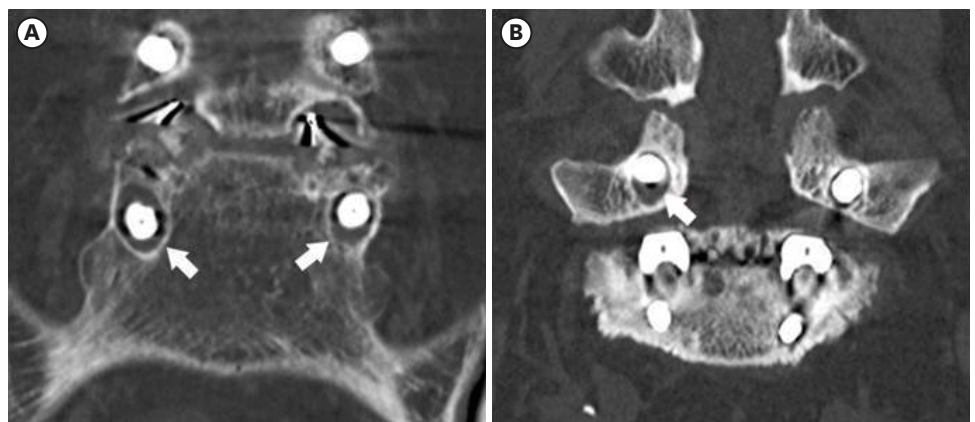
Main halo formation location on coronal computed tomography scan (arrows). (A) Whole type. (B) Inferior type.
